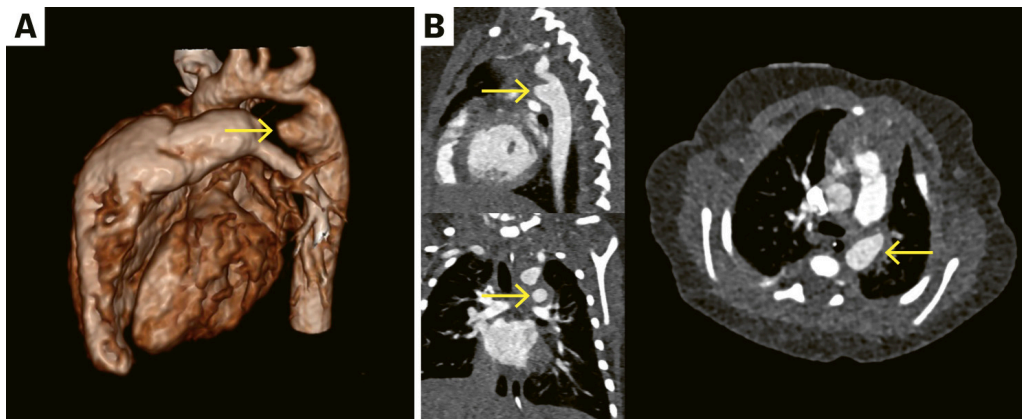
CT angiography showing an aneurysm of the ductus arteriosus (arrows), with 3D volume rendering (A) and multiplanar reconstructions (B).
